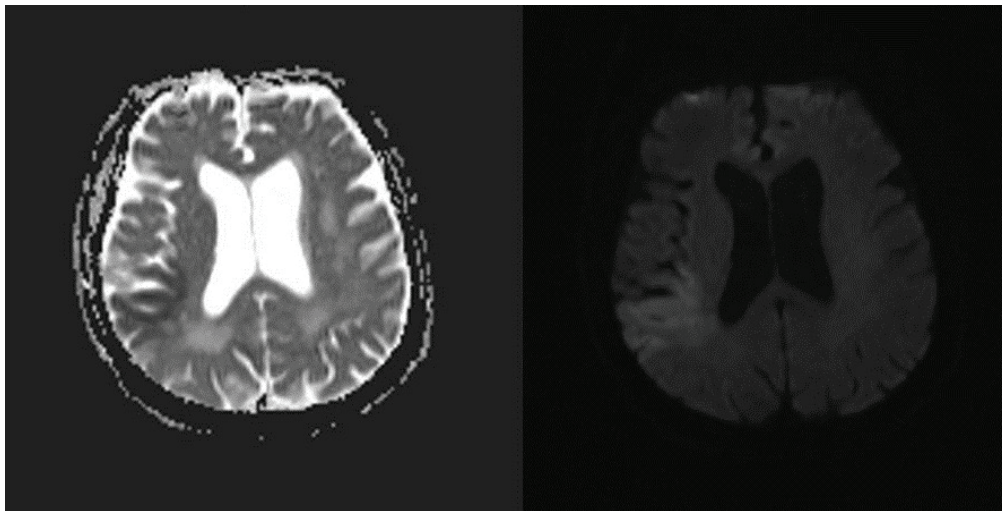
Axial apparent diffusion coefficient (ADC) (left) and diffusion-weighted (DWI) (right) magnetic resonance images (MRI) revealing cortical and subcortical patchy areas of restricted diffusion in parietotemporal region compatible with acute ischemia.
